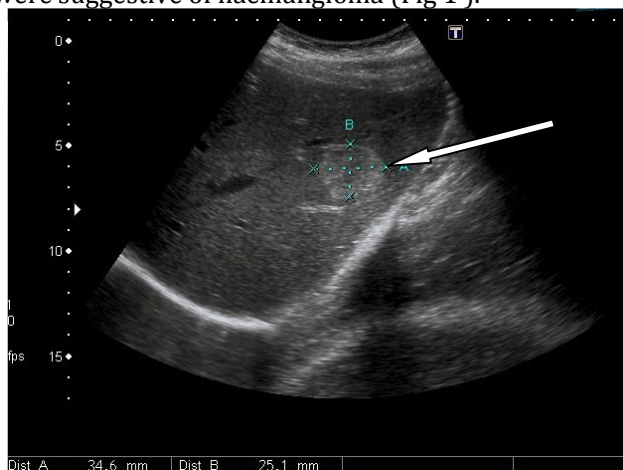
Ultrasonogram Depicting Hyperechoic Haemangioma in the Left Lobe of Liver
